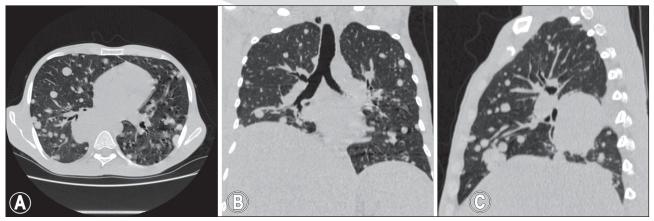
Toraco-pulmonary computed tomography (a. axial view, b. coronal view, c. transversal view) show relatively well defined voluminous tissue mass, with maximum axial dimensions of 59/46 mm situated infrahilar medial-basal on the right side, in contact with the mediastinal and costo-vertebral pleura; and also multiple nodular and micronodular formations, clearly defined, with axial dimensions between 4 and 28 mm, disseminated in both lung fields
